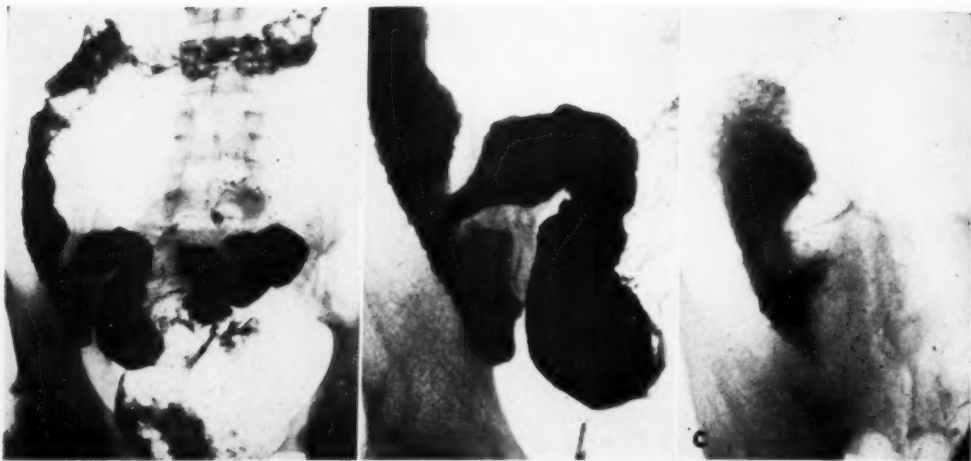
Case 5: A. S., an 18-year-old white male, had advanced pulmonary tuberculosis. Though there were no gastro-intestinal symptoms, roentgenograms show indisputable ileocecal tuberculosis. This condition was discovered during an attempt to establish the etiology of a rapid pulse. The absence of clinical symptoms is a not unusual occurrence in this disease.
